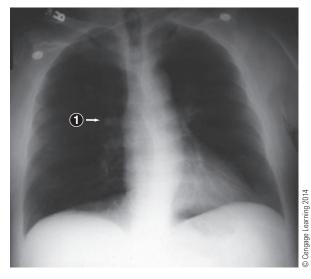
Smoke inhalation. The chest radiograph is normal. The lungs typically are not affected unless there is edema formation secondary to smoke inhalation. The small round marking (1) represents a pulmonary blood vessel running parallel to the roentgen ray (X-ray).
